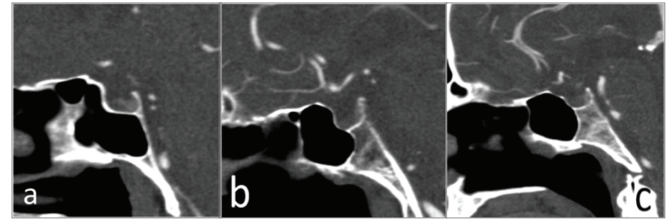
Degree of sellar bulging. Sagittal computed tomography angiography images show prominent (a) and mild (b) sellar bulging. In (c), no sellar protrusion to sphenoid sinus is seen.
